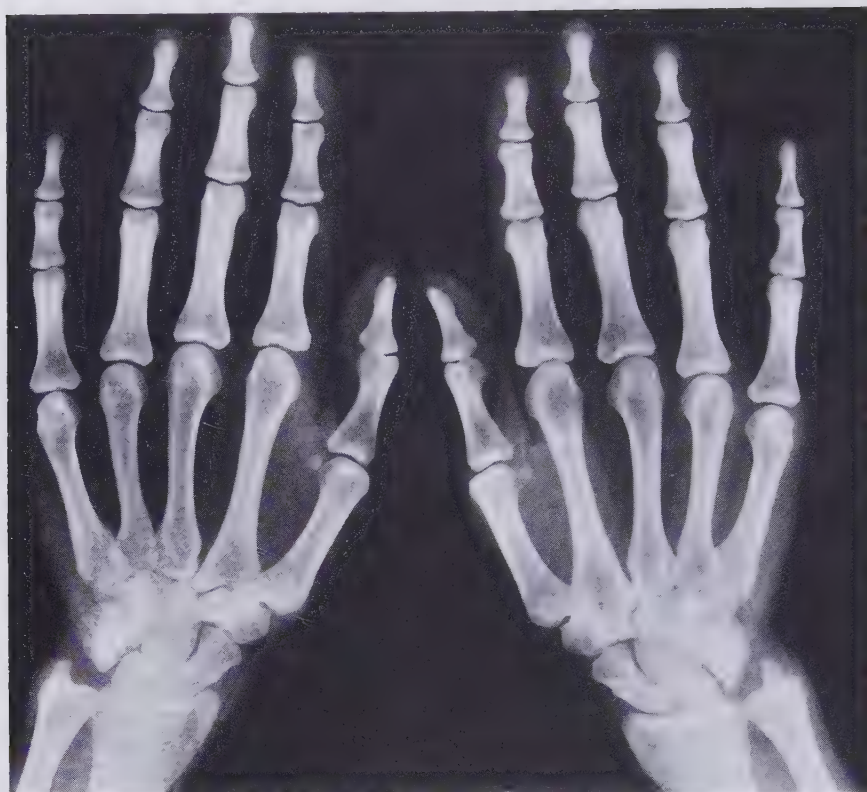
X-ray views showing the skeleton of both hands. The thumb metacarpal is the shortest and the index metacarpal by far the longest. The proximal and middle phalanges of the long and ring fingers are longer than those of the index finger. Note the interlocking design of the carpometacarpal articulations and the saddle shape in opposing planes of the articular surfaces of the trapezium and the base of the first metacarpal.
